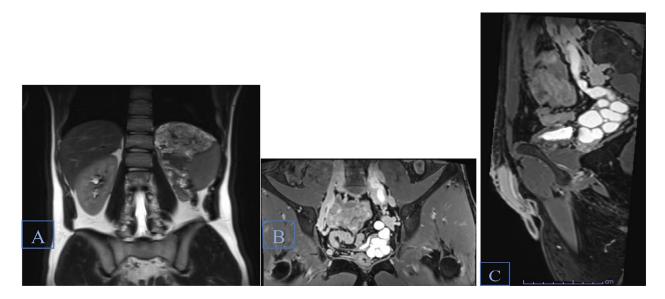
(A) Coronal T2-weighted MRI of the abdomen and pelvis showing the absent left kidney. (B,C) Coronal and sagittal T1-fat suppression images showing a tubular structure extending from the left side of seminal vesicle in the left pelvic and lumbar region that ends abruptly at the level of L4, representing the atretic left ureter. Both the atretic left ureter and the seminal vesicle show hyperintense signal content indicating hemorrhagic/high proteinaceous contents.
